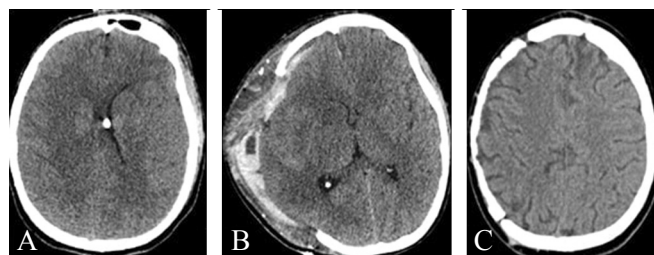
CT of patient #2. A) Before craniectomy brain CT; B) postcraniectomy brain CT; C) postcranioplasty brain CT.
